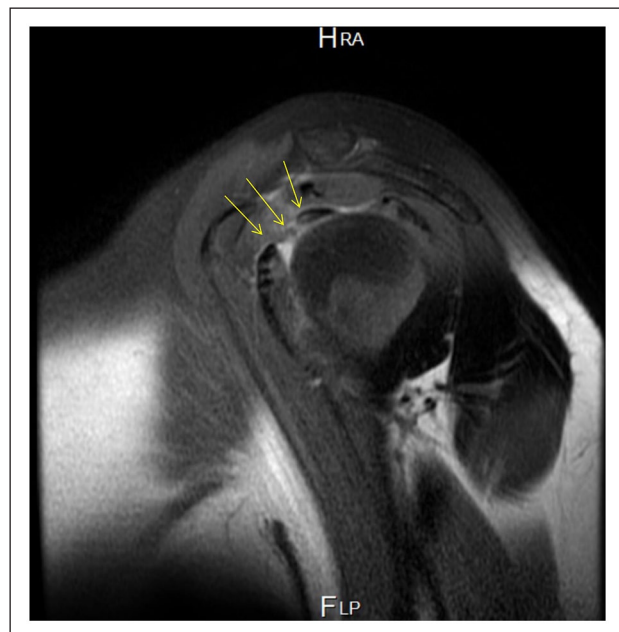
Magnetic resonance imaging of the left shoulder showing soft tissue thickening of the rotator interval.
